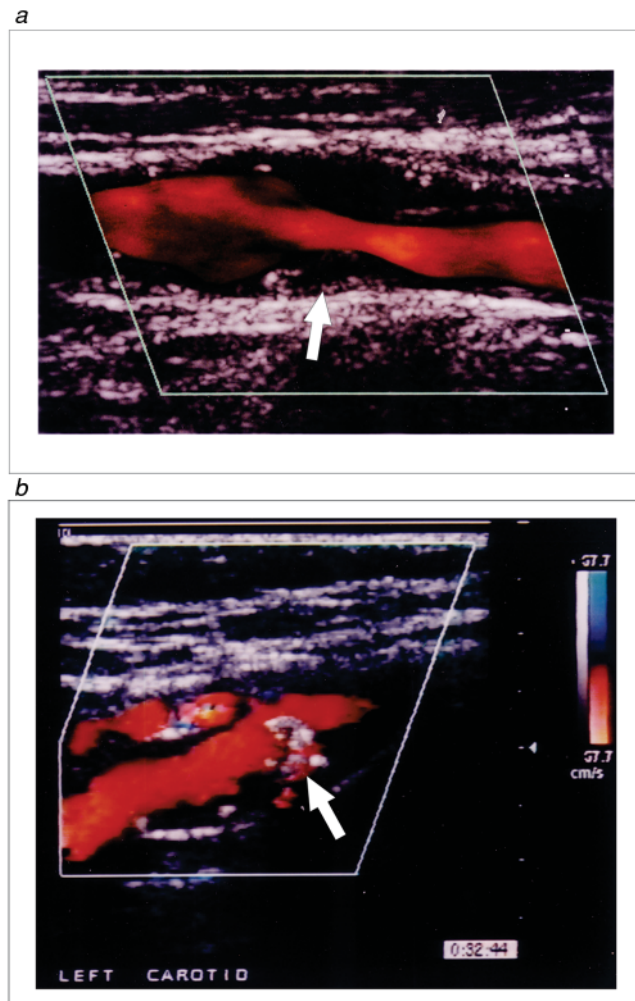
(a) Color duplex ultrasound image of the carotid bifurcation showing a complex heterogeneous plaque at the origin of the internal carotid artery (arrow). (b) Color duplex ultrasound image of the carotid artery showing a smooth heterogeneous plaque (arrow). The dark center of the plaque may represent intraplaque hemorrhage. Reproduced with permission from Duplex scanning of the carotid arteries. In: AbuRahma AF, Bergan JJ, editors. *Noninvasive Vascular Diagnosis: a Practical Guide to Therapy*. London: Springer; 2007. p. 70.
